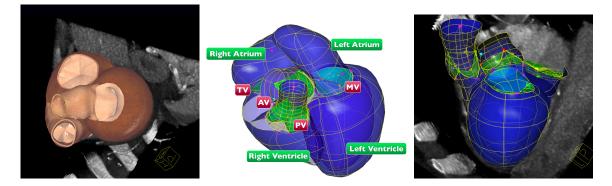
Examples of estimated personalized model from a multiphase CT sequence. The images are extracted from the end-systolic phase.
